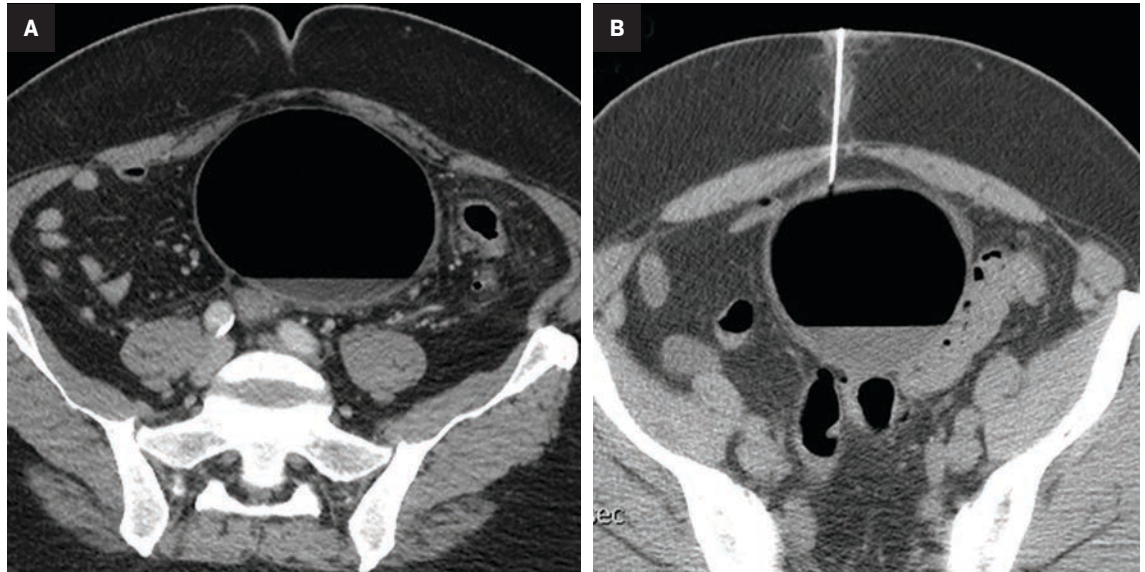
(A) CT of the abdomen in a middle-aged adult reveals a 9 cm GSD with very thin walls. (B) CT-guided needle insertion into the lesion prior to placing a pigtail catheter. Drainage of gas and sero-sanguinous fluid reduced the lesion and led to its resolution.
